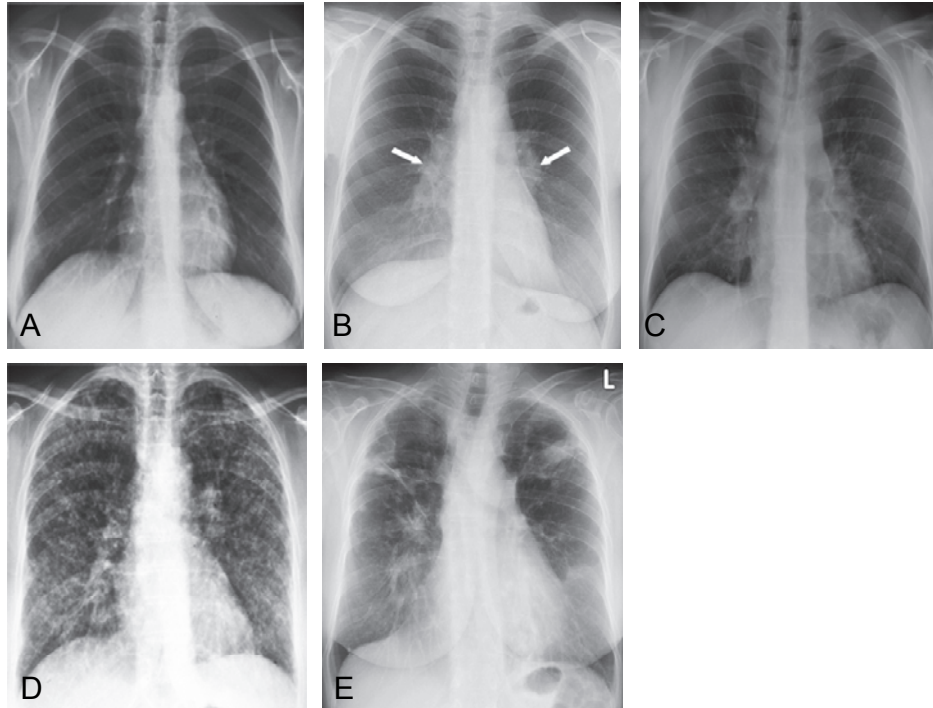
Chest X-ray stages 0-IV: radiographic appearances of sarcoidosis.
